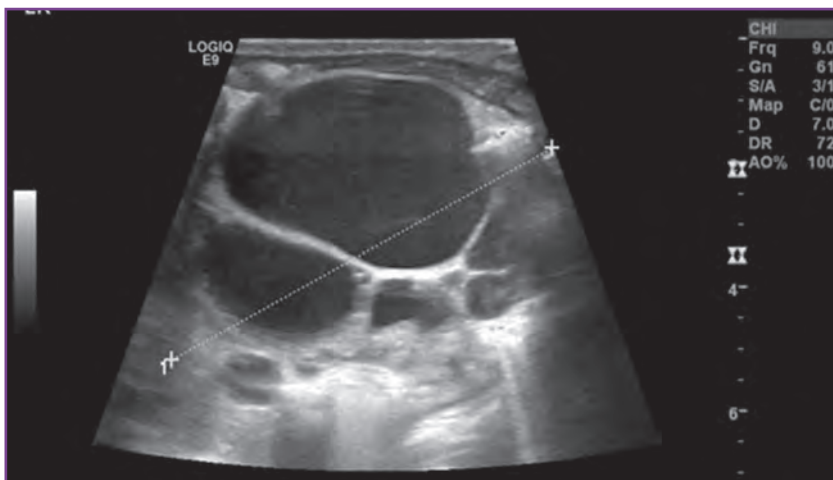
Postnatal ultrasonography demonstrates a multicystic dysplastic kidney.
